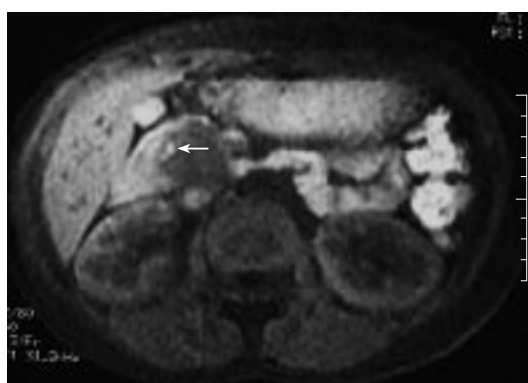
Precontrast T1-weighted axial MR image shows that the mass is predominantly hypointense and the hyperintense focus represents hemorrhage (arrow).
